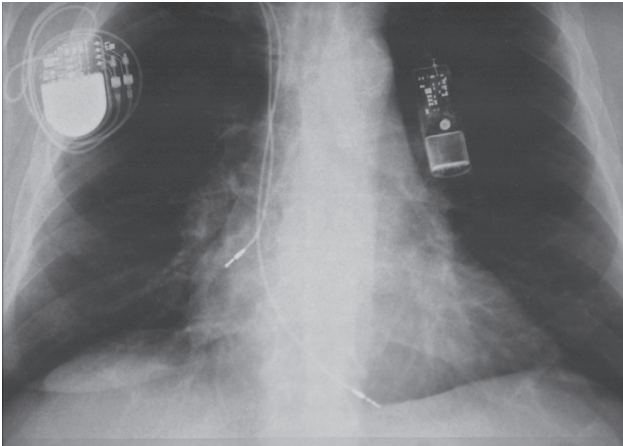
Chest X-ray with the implanted devices (dual chamber pacemaker and ILR).
